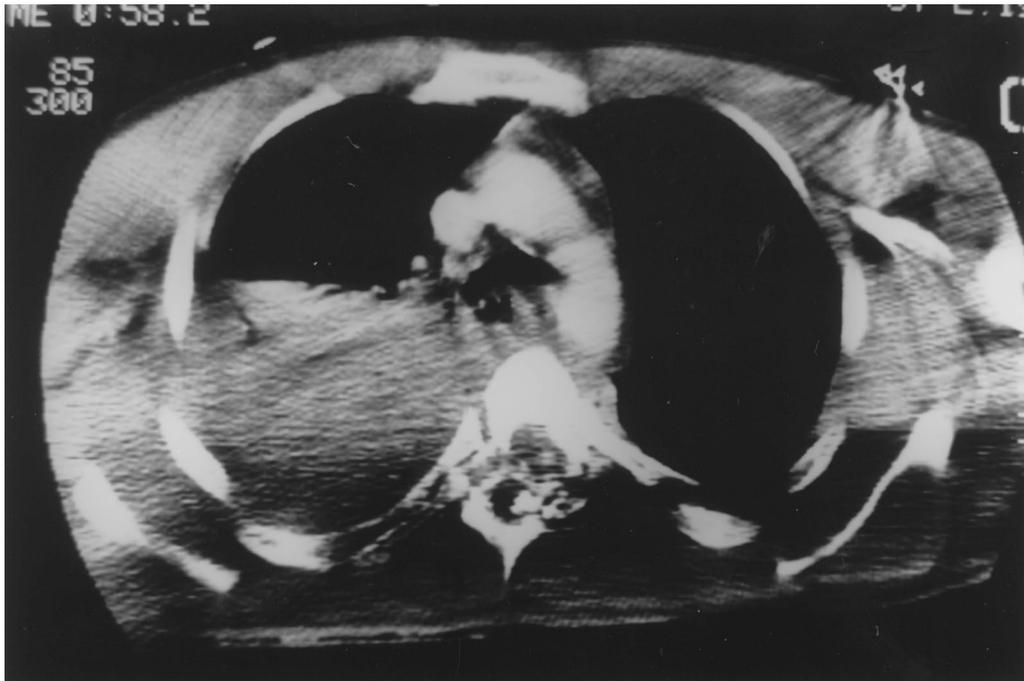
CT scan of the chest showing displacement of the spine as a “double” image, and collection of blood in the right haemothorax.
